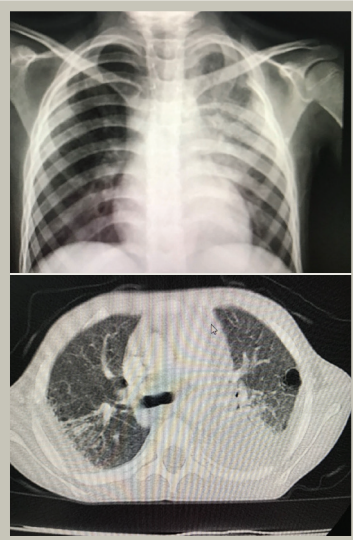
Chest radiography and thorax CT of the patient
